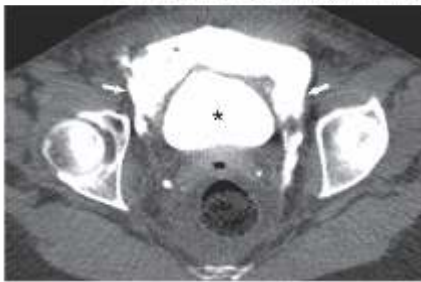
Urine leak after placement of a midurethral sling in a 58-year-old woman. Axial CT cystogram shows the urinary bladder (*) with adjacent extravasated contrast material in the space of Retzius (arrows), an appearance referred to as the “molar tooth sign.”
